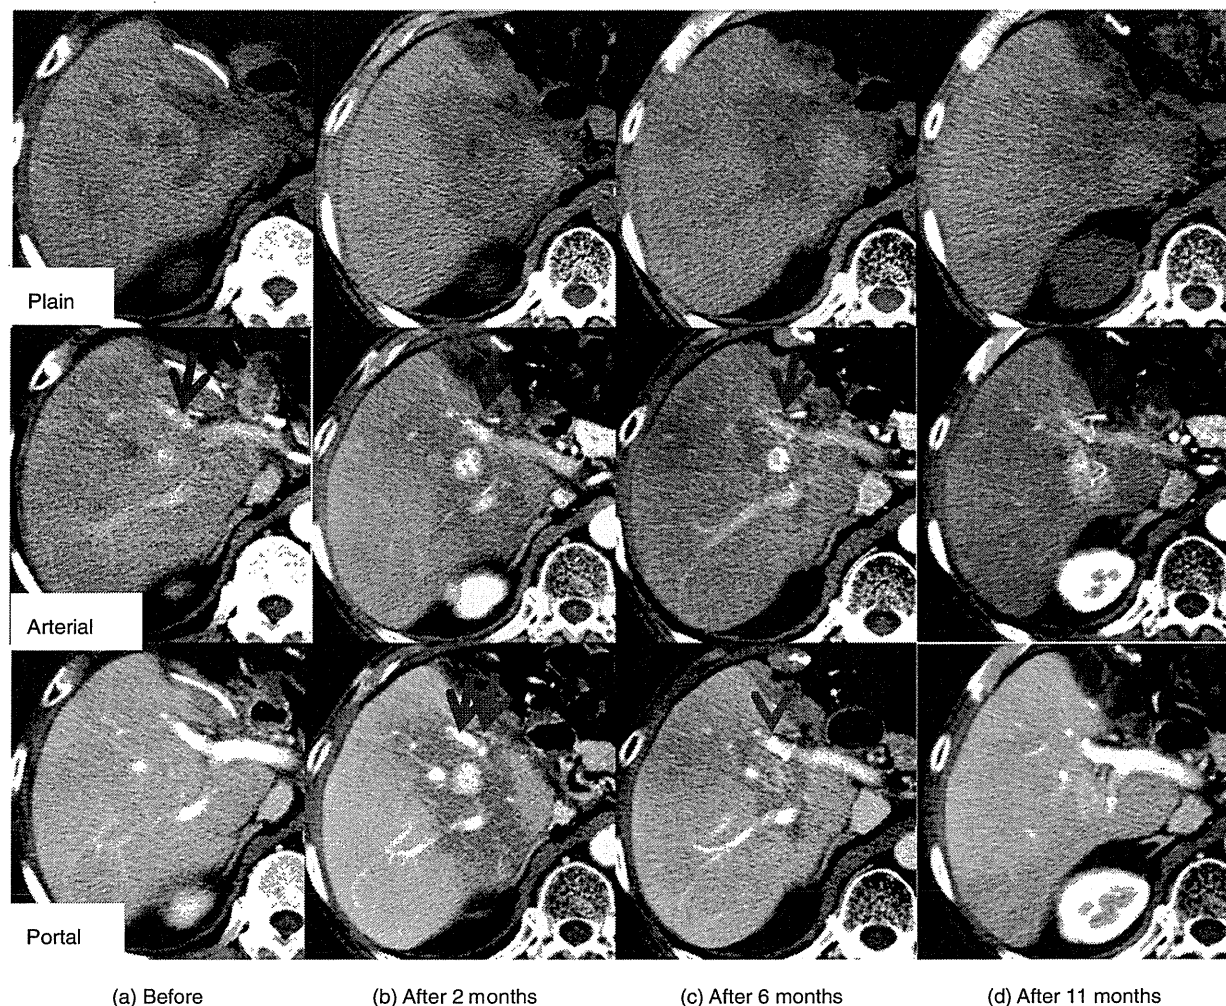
Dynamic computed tomography appearance of tumor response type 3 (plain, arterial and portal phase in case 39). (a) Before stereotactic body radiation therapy (SBRT), early arterial enhancement is visible (red arrow). (b) Two and (c) 6 months after SBRT, early arterial enhancement is more evident than that before SBRT in arterial (red arrow) and portal phase (two red arrows). (d) Eleven months after SBRT, although shrinking, it remains (red arrow).
